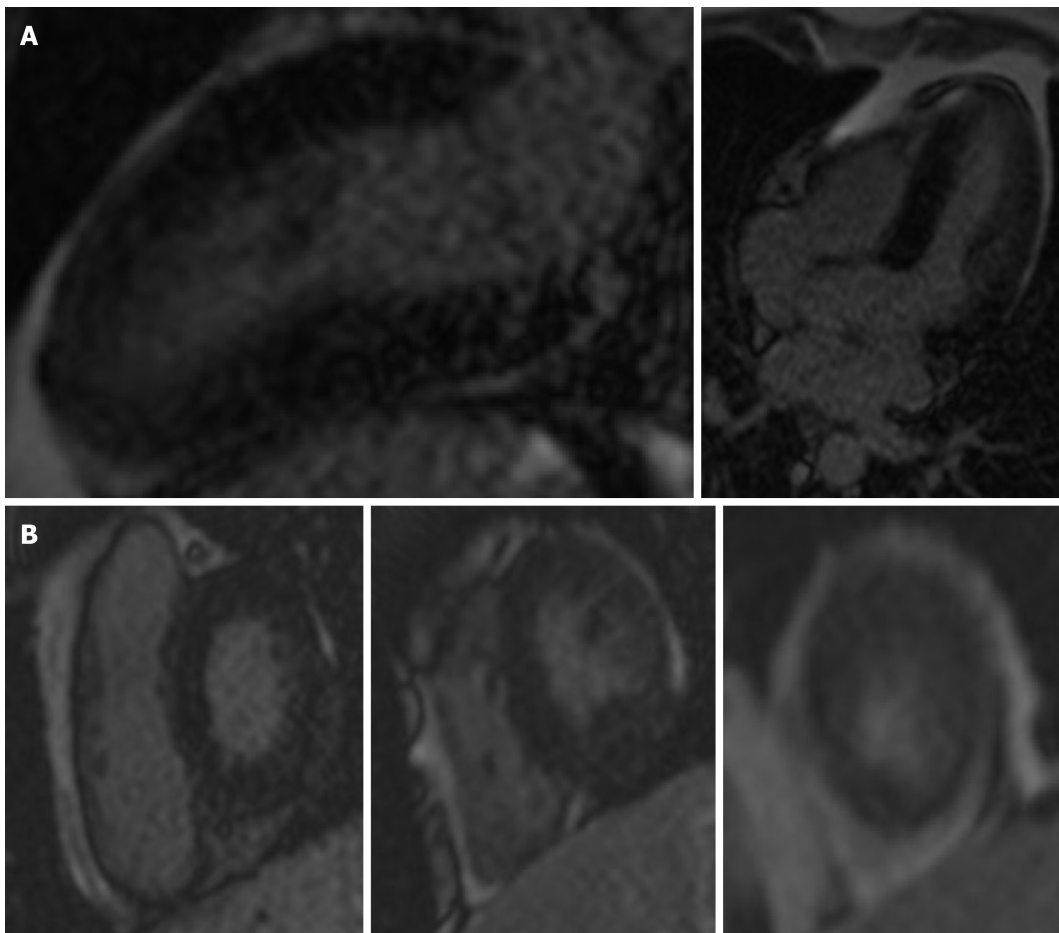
Cardiac magnetic resonance imaging. A: Absence of any late gadolinium enhancement in 4 chamber and 2 chamber; B: Absence of any late gadolinium enhancement in basal, mid and apical left ventricle on short axis.
